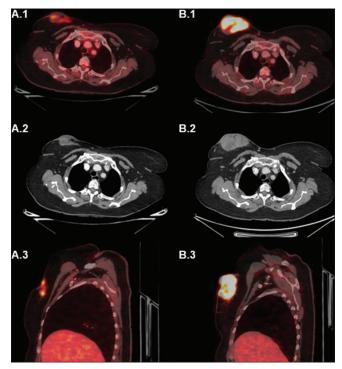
A 65-year-old female was diagnosed with carcinoma left breast - cT4bN1M0, estrogen receptor-positive, progesterone receptor-negative, human epidermal receptor 2 neu negative, and Ki67 33% (Luminal B type). She was planned for neoadjuvant chemotherapy and received four cycles of 3-weekly adriamycin and cyclophosphamide followed by 12 cycles of weekly paclitaxel. The initial staging positron emission tomography-computed tomography (PET-CT) fused images show fluorine-18 fluorodeoxyglucose accumulation in the primary lobulated lesion with the cystic component in the left breast infiltrating the skin (A.1), also seen on CT images (A.2), and in PET-CT fused sagittal images (A.3). The postchemotherapy PET-CT fused sagittal images (B.1), also seen in CT images (B.2), and in PET-CT fused sagittal images (B.3). The PERCIST grading and NIMS grading system (Grade 16) are suggestive of progressive disease
